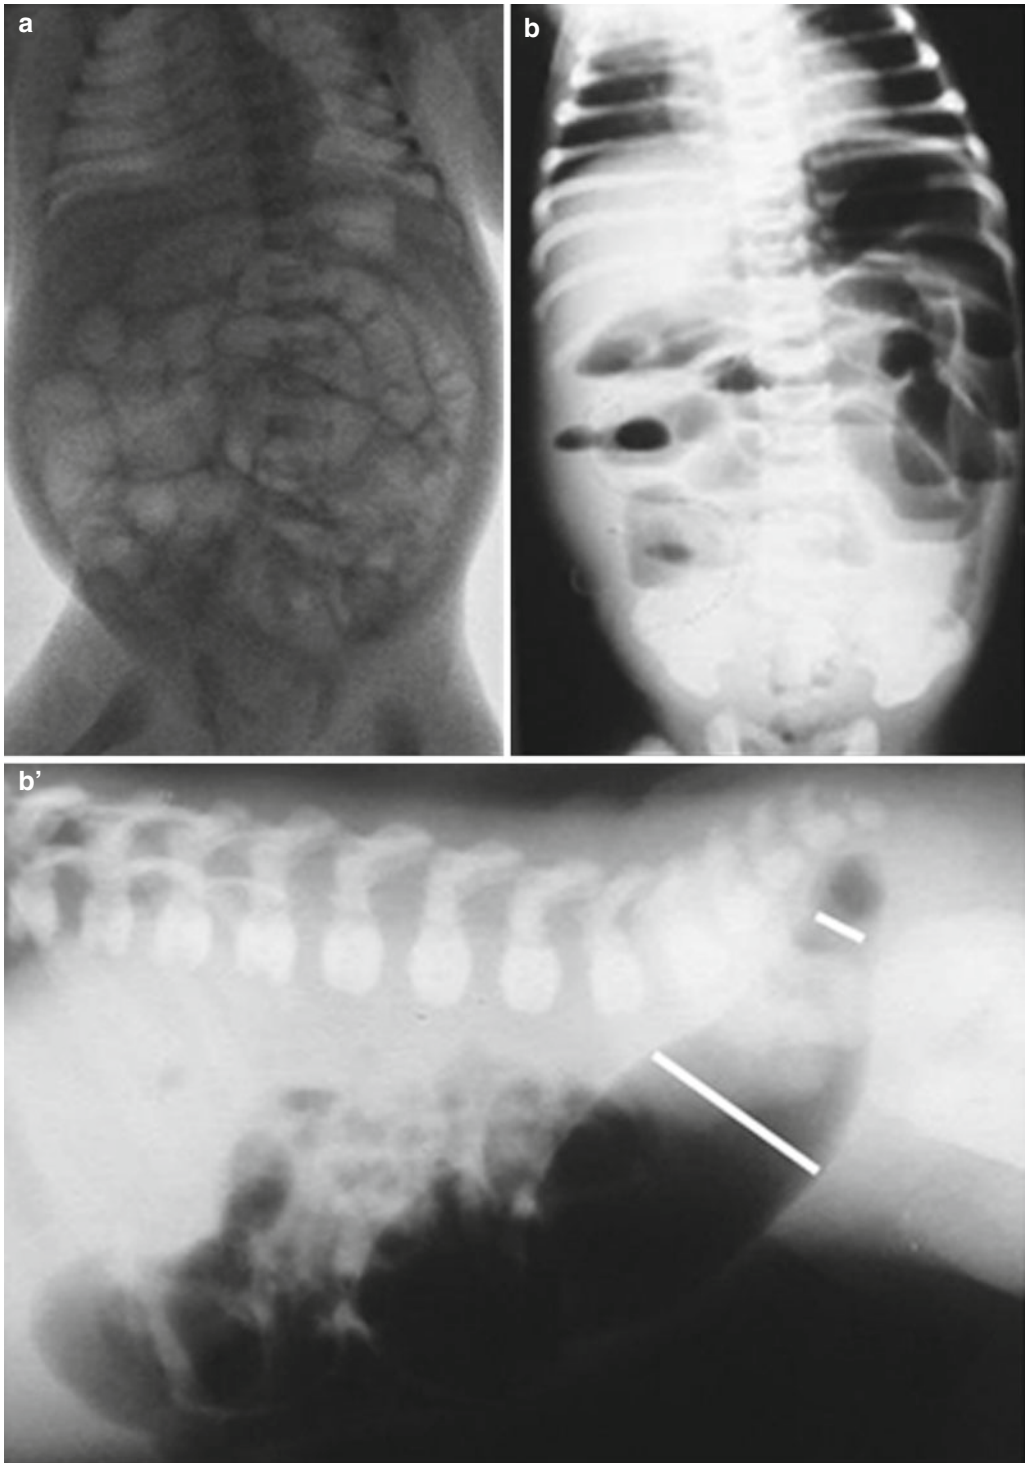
Plain film in HD: (a) widespread intestinal dilatation in HD. (b-b') Another case of HD. (b) A-P plain film: intestinal dilatation but with little bloating in the rectosigmoid region; (b') the lateral view in prone position
